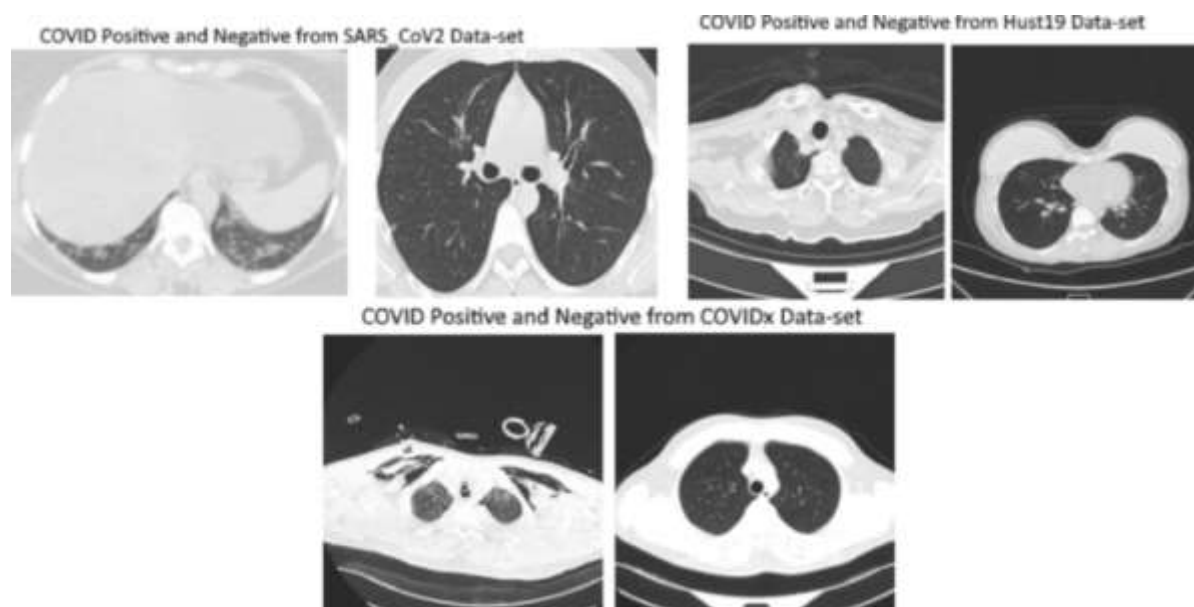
Representative chest CT examples from the HUST-19 imaging resource, showing COVID-positive and COVID-negative CT appearances. Source: adapted from Mehboob et al. (2022), Figure 4, which includes HUST-19 images; HUST-19/iCTCF source resource described by Ning et al. (2020). The linked article is licensed CC BY 4.0; the original HUST-19 resource is available for academic use under CC BY-NC 4.0. These images provide radiological context and are not linked to individual outcome records in the present tabular analysis.
